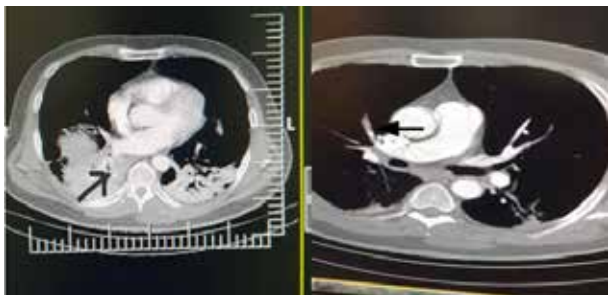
CT scan demonstrating filling defects within the sub segmental branch of right lower lobe (right) and segmental branch of right upper lobe (left).
